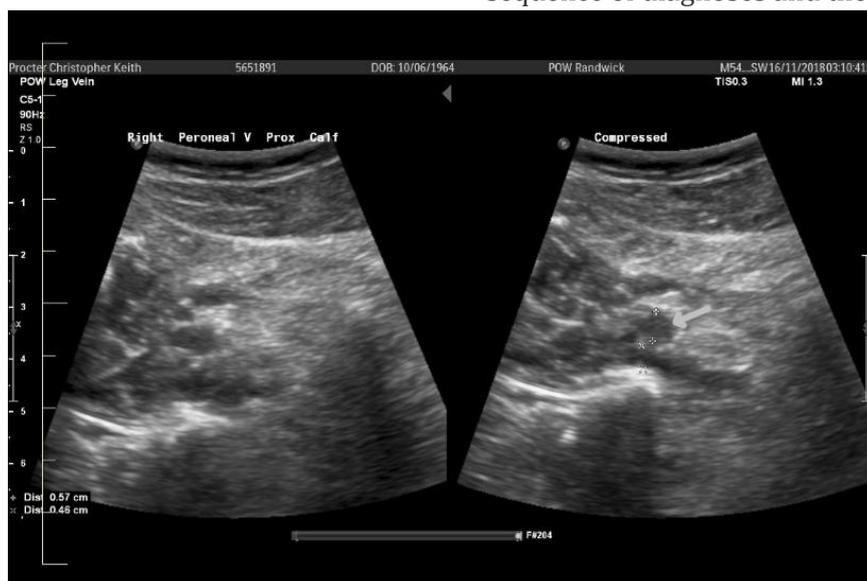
Venous Doppler study showing non compressible thrombus in deep calf Peroneal vein
